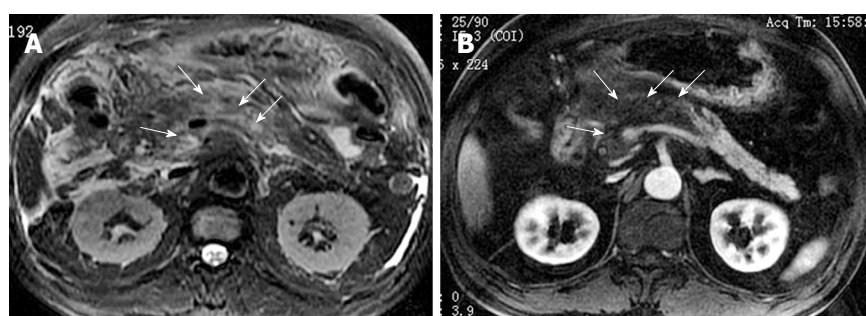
65-year-old man with acute pancreatitis. Axial T2-weighted image (A) shows the high-signal intensity in the pancreatic head and body (arrows). The arterial phase MR image (B) shows a large necrotic area ("black pancreas") in the pancreatic head and body (arrows).
